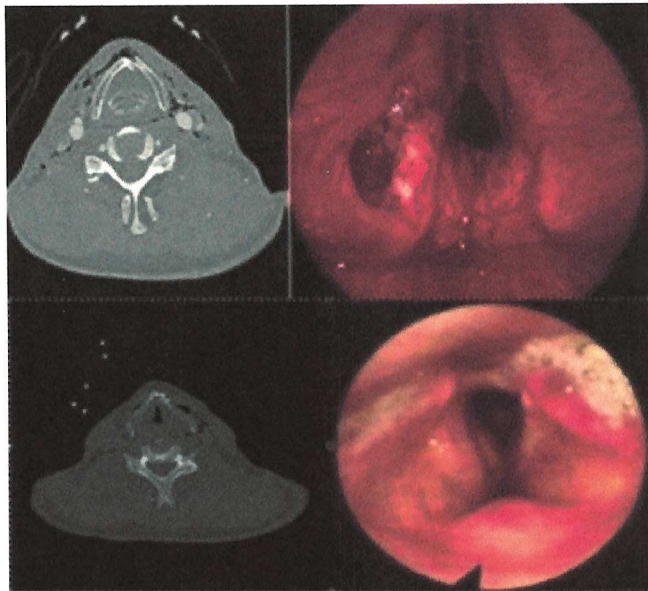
(Up) Preoperative CT scan and fibre endoscopic examination (case 1) show a displaced fracture of the thyroid cartilage on the left side with extensive emphysema and a laceration of the mucosa. (Down) Postoperative CT scan and 1-month postoperative fibre endoscopic examination (case 1) show symmetric alignment of the thyroid cartilage with regression of the emphysema and good healing of the laryngeal mucosa with normal vocal fold mobility and no endolaryngeal exposure of the miniplates or screws.
